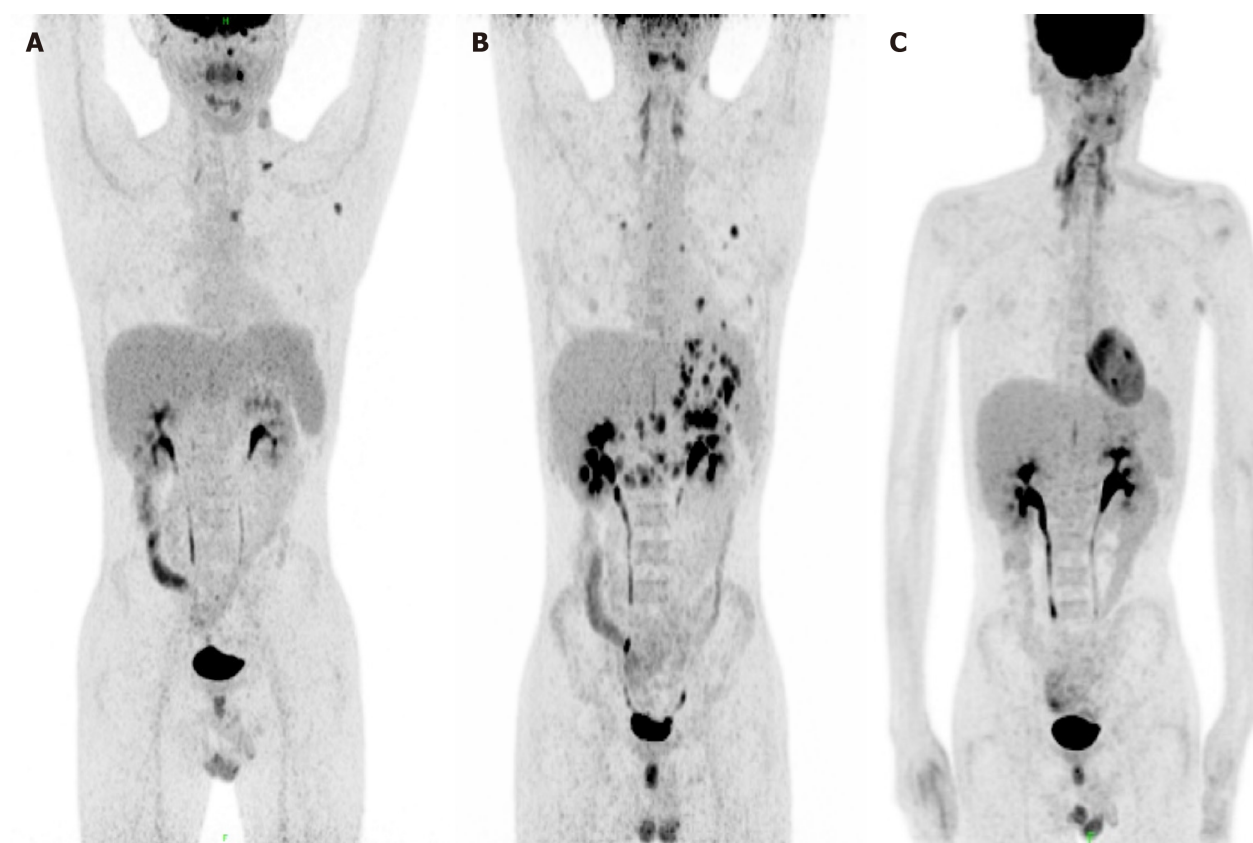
18F-FDG PET scan of the patient during treatment. A: Pre-treatment; B: Newly onset of stomach and lung lesions; C: Post-treatment.
